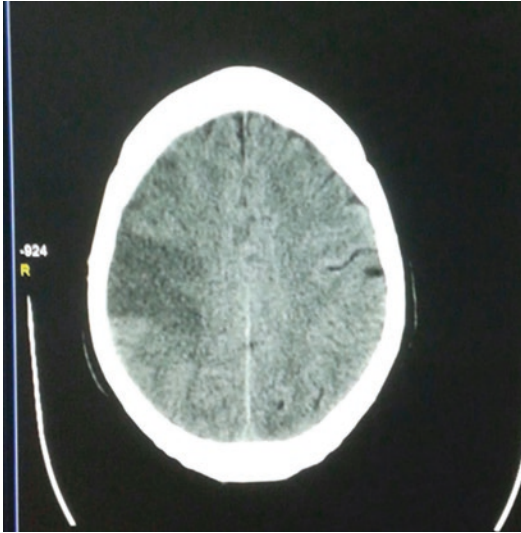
Computed tomography of the skull showing the stroke
